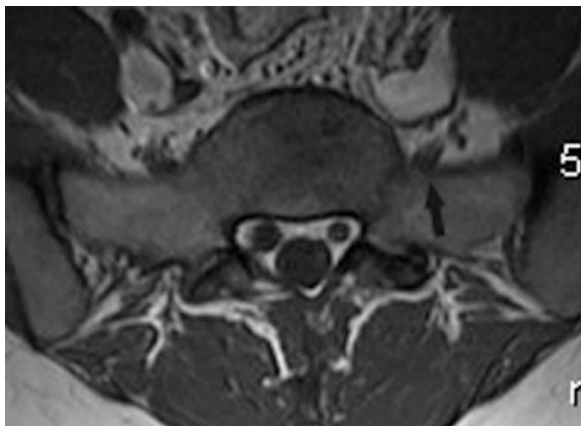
An axial magnetic resonance imaging (MRI) image with the *arrow* pointing at the *left* L5 root as it abuts the sacral ala making it vulnerable to injury if an iliosacral screw is inadvertently directed too anterior
